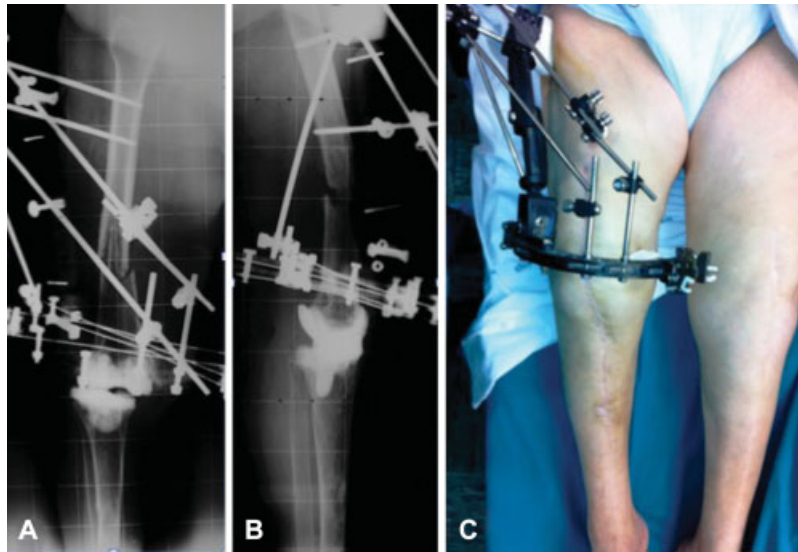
Anteroposterior (A) and lateral (B) X-rays and clinical images (C) show the Orthofix hybrid external fixation.
